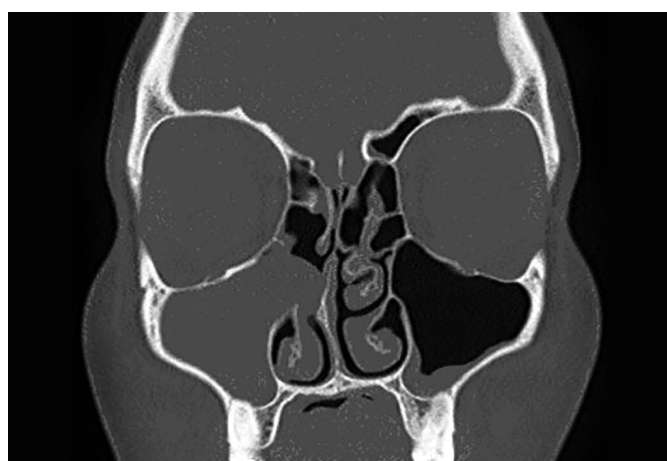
Coronal computed tomography scan of a patient with asymmetric height of the fovea ethmoidalis. Attention to this potential variant is important when planning endoscopic ethmoidectomy to avoid inadvertent skull base injury (more likely on the lower side) while not leaving residual cell partitions (more likely on the higher side).
